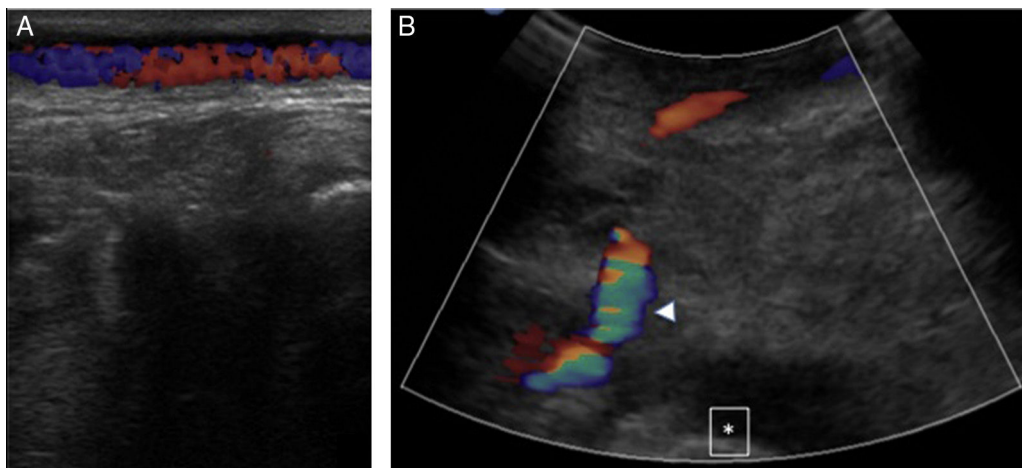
Eco-Doppler: bypass control. (A) Superficial pathway of the in situ SVG. (B) Permeable bypass (arrow head). Femoral condyle (asterisk).
